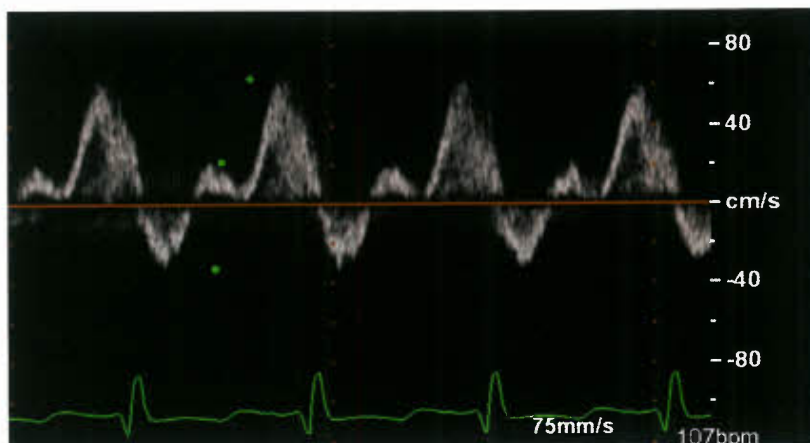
This Doppler profile is from a child with significant MV regurgitation in the presence of normal left ventricular function. Note the flow reversal in the pulmonary vein profile during ventricular systole.
